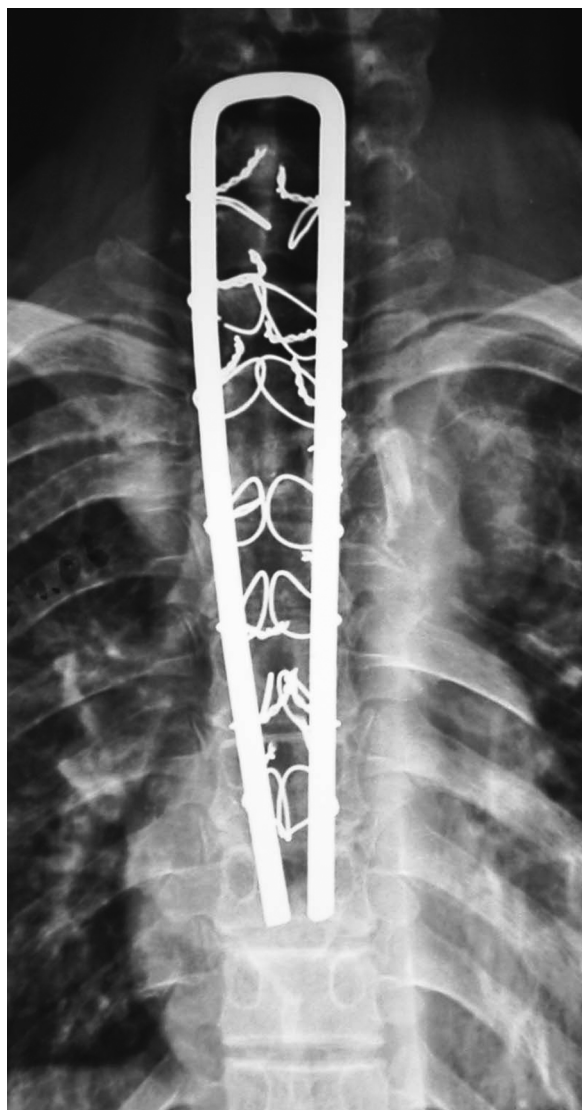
Postoperative radiograph shows the use of an open Hartshill implant (inverted U) in a child.
